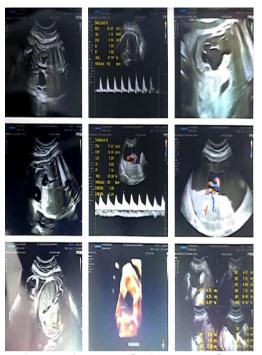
Anomaly Scan Doppler study
